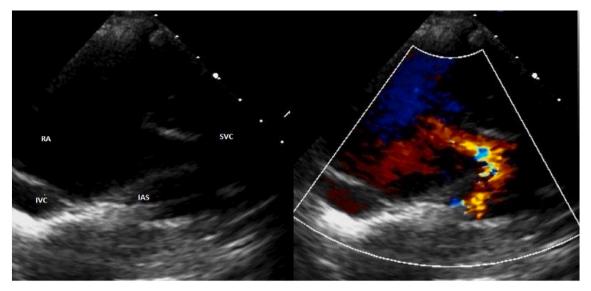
High right parasternal view of atrial septum - sinus venosus atrial septal defect.
